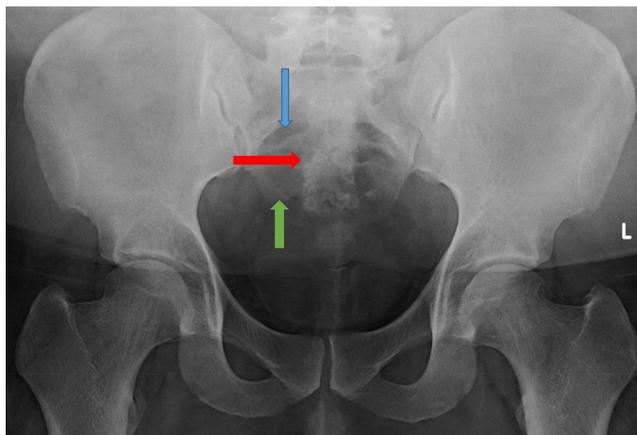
Single anteroposterior view radiograph of the pelvis demonstrate mixed sclerotic and lytic lesion with in the sacrum. This mass demonstrates central sclerotic component (*red arrow*) with surrounding lytic component (*green arrow*). There is also distortion of the sacral arcuate lines (*blue arrow*)
